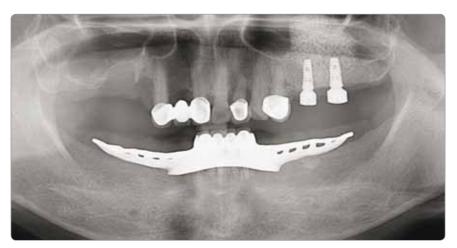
Post-op radiography
